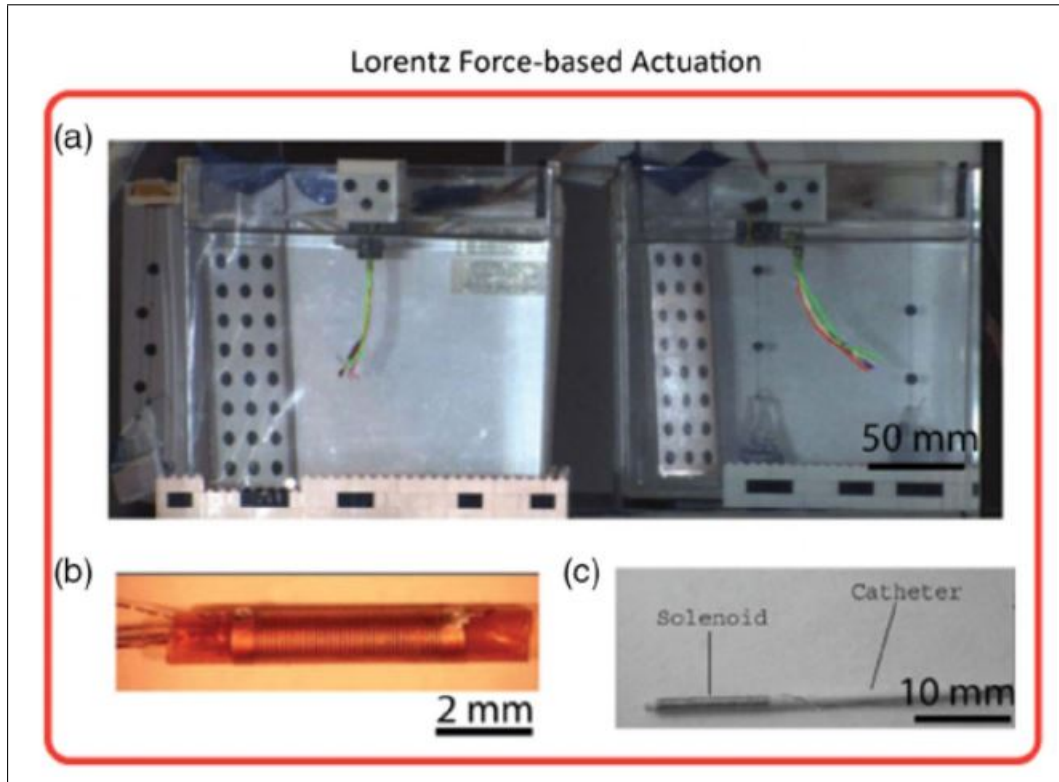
Examples of MRI-driven robots actuated by the Lorentz forces in the literature. aâ c) MRI-driven catheters with Lorentz coil embedded. [23]-[24] The torque induced on an active Lorentz coil deforms the tip, which enables precise tip control within MRI.
